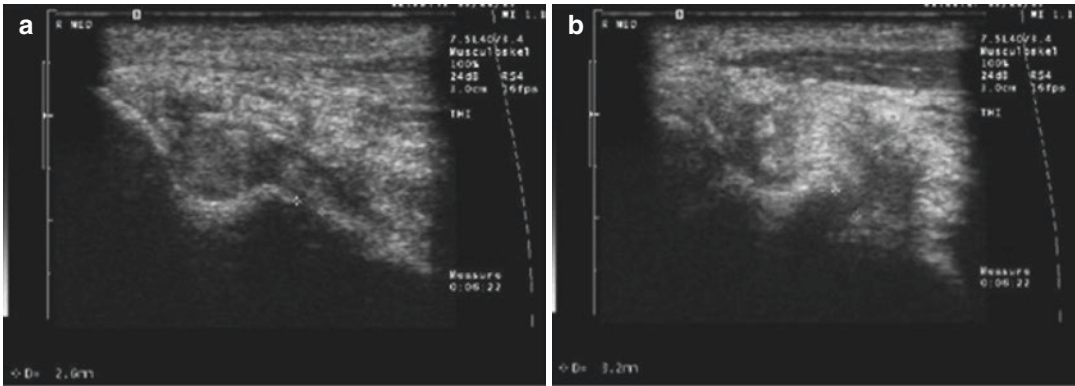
Stress ultrasound demonstrating (a) ulnohumeral joint space width of 2.6 mm in the reconstructed elbow at rest; (b) minimal increased ulnohumeral joint
